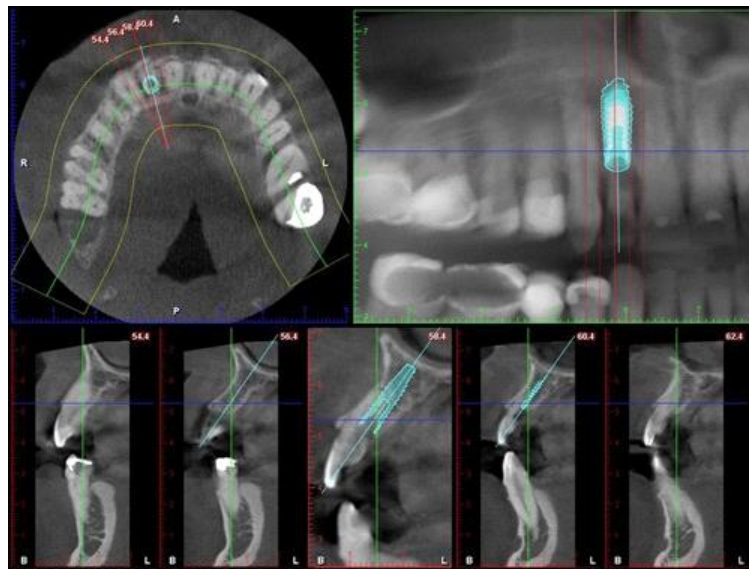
CT plan - shows 3.8x15 implant. I will actually position platform lightly more palatal than shown to get screw access through lingual
